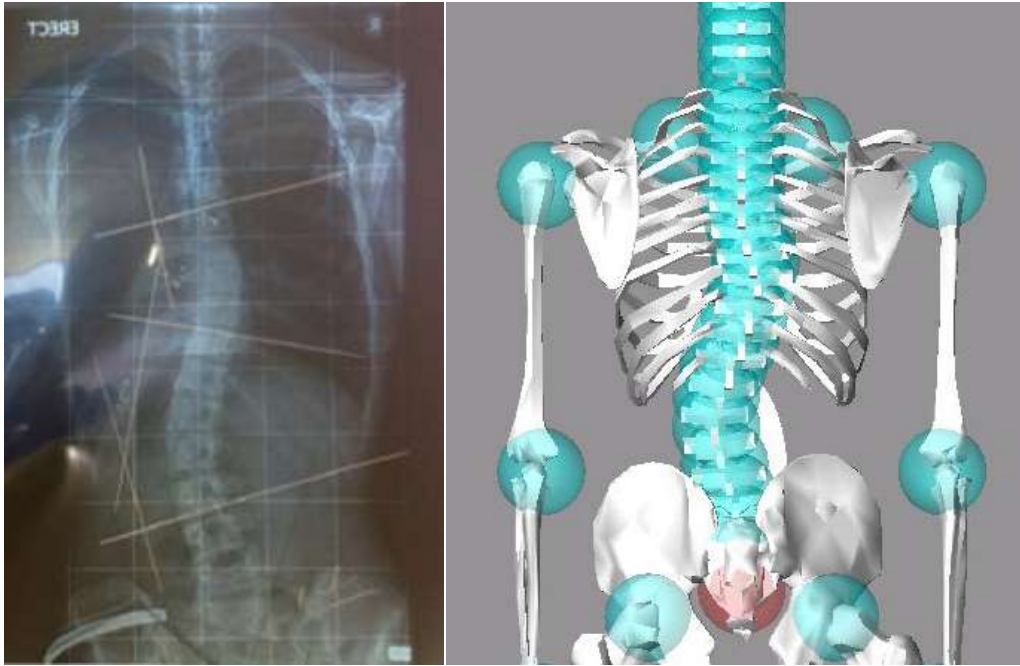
The back view of X-ray image and the 3D body model of the subject
